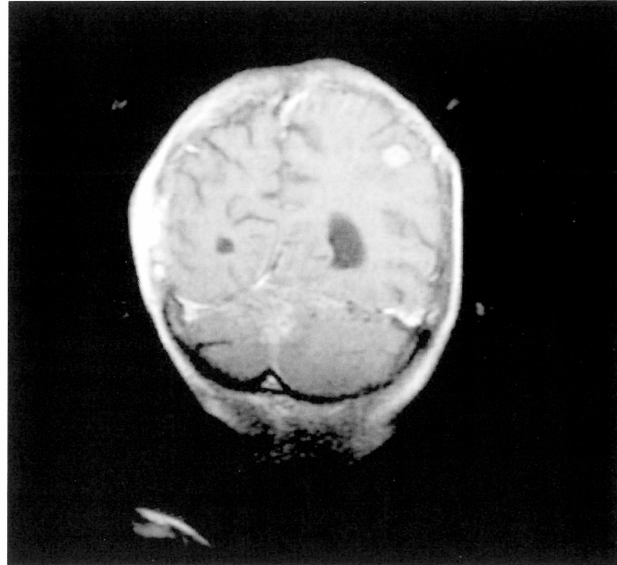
Coronal view of MRI showing left precentral gyrus metastases.
